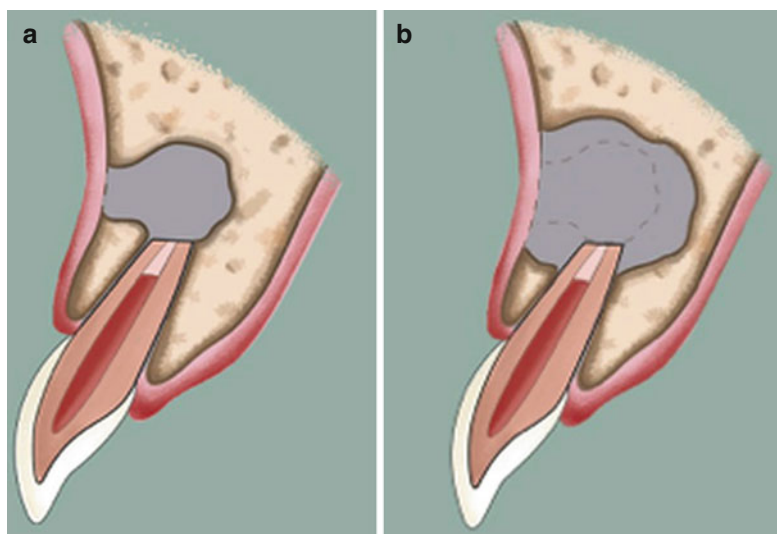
Complete healing. (a) Surgical bony defect after endodontic surgery. (b) Significant reduction in size of a periapical bony defect by bone formation from periphery. Note that the size of the bony defect is no greater than
